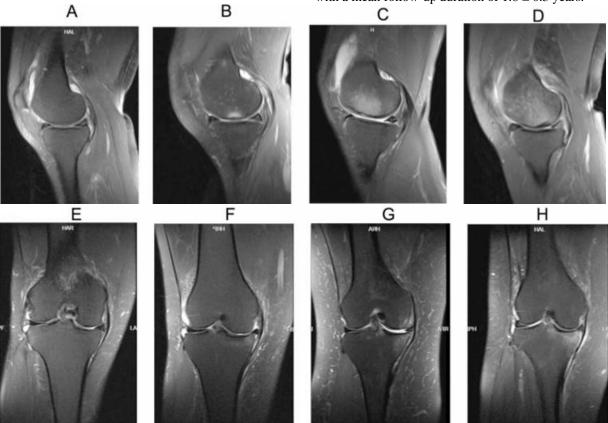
BME was assessed based on the MRI Osteoarthritis Knee Score (MOAKS). Medial femoral condyle and medial tibial plateau: (A, E) grade 0, (B, F) grade 1, (C, G) grade 2, and (D, H) grade 3. MRI, magnetic resonance imaging
